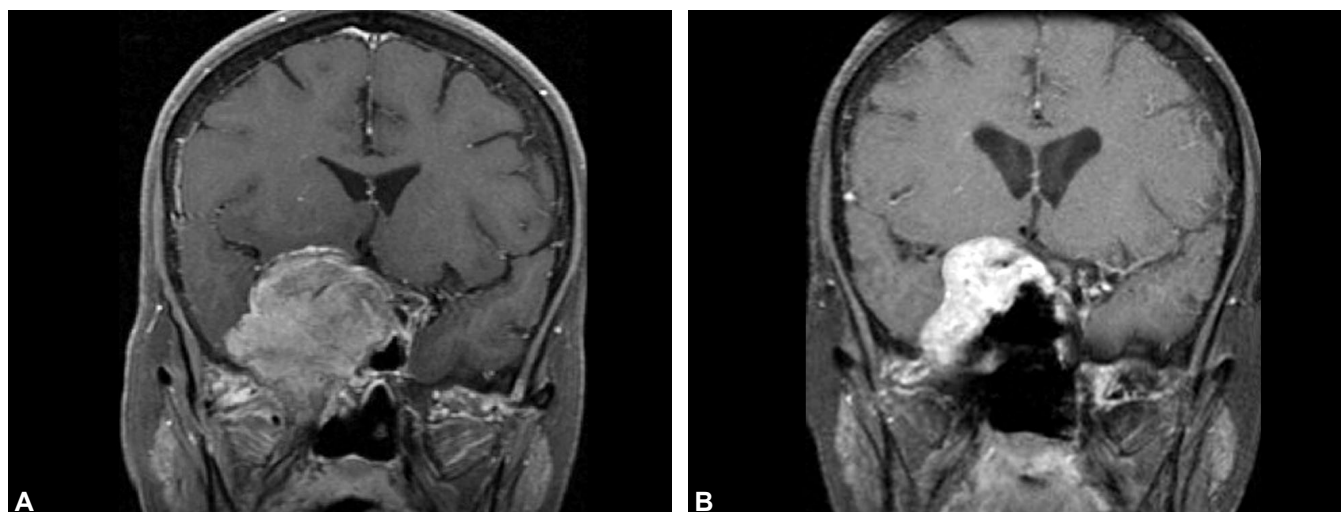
Preoperative (A) and postoperative (B) magnetic resonance imaging (MRI) of a squamous cell carcinoma (SCC) with encasement of the internal carotid arteries (arrows) that underwent endoscopic debulking prior to definitive radiochemotherapy. (FG: Fat graft).
